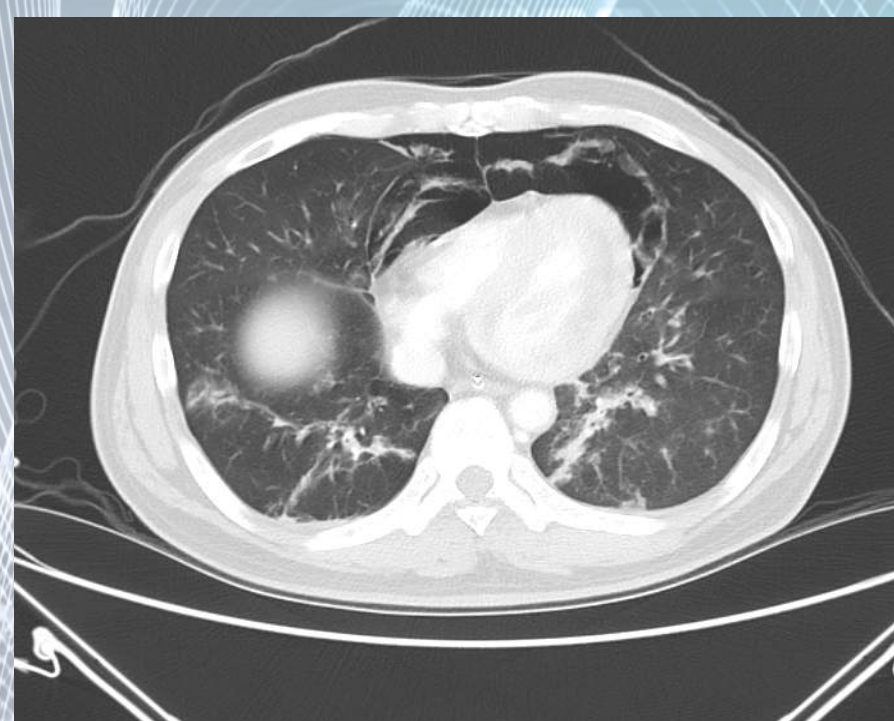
represent CT Thorax of the patient showing the heart was compressed by pneumomediastinum
